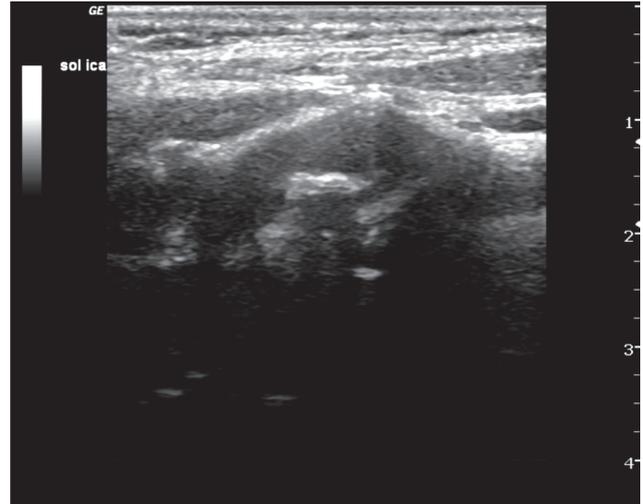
Doppler ultrasound imaging of the left carotid artery of the patient.
